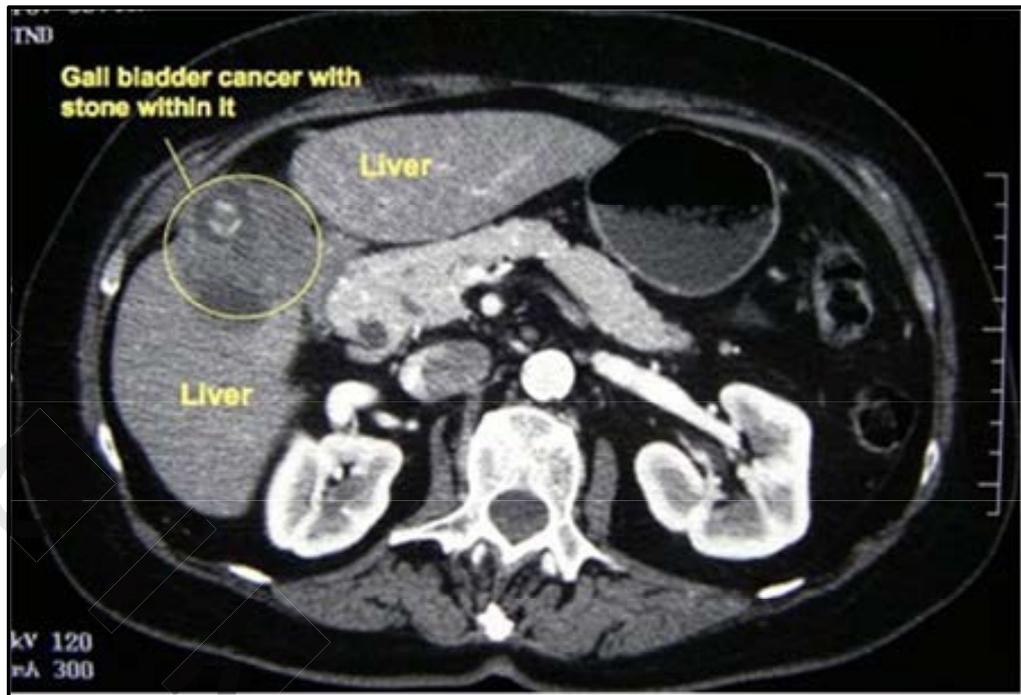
CT image of cancer gall bladder.⁽⁷⁰⁾
